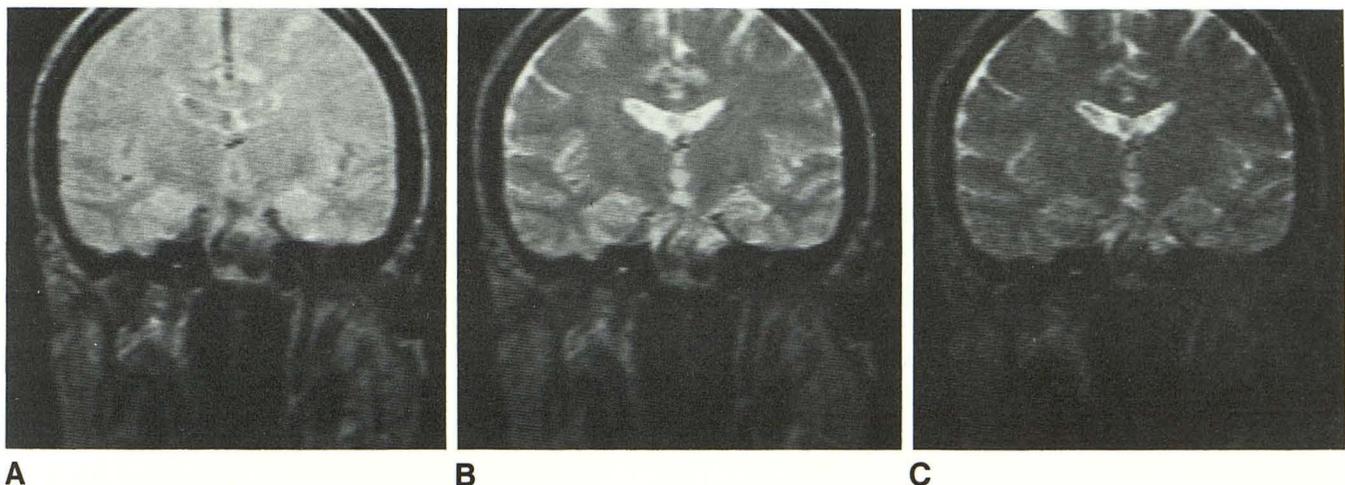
A–C, Coronal T2-weighted MR images obtained in a human volunteer with fast spin-echo pulse sequences (800/96). The excitation flip angles are 90° (A), 30° (B), and 10° (C). The optimum CSF-white matter contrast is obtained with a flip angle of 30°, as shown by the plot in Fig. 3. CSF regions of interest were not taken from the lateral ventricles, where there is significant CSF motion artifact, but from other areas of relatively static CSF (interhemispheric fissure, third ventricle, or interpeduncular fossa).
